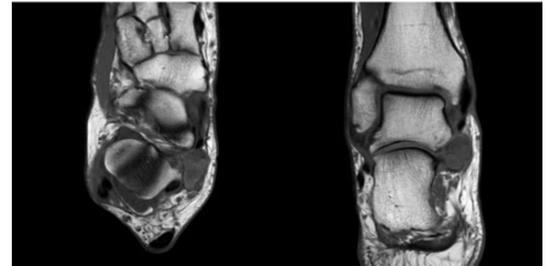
T1 MRI axial and coronal views demonstrating a ganglion cyst positioned within the tarsal tunnel, arising from the posterior subtalar articular articulation.
